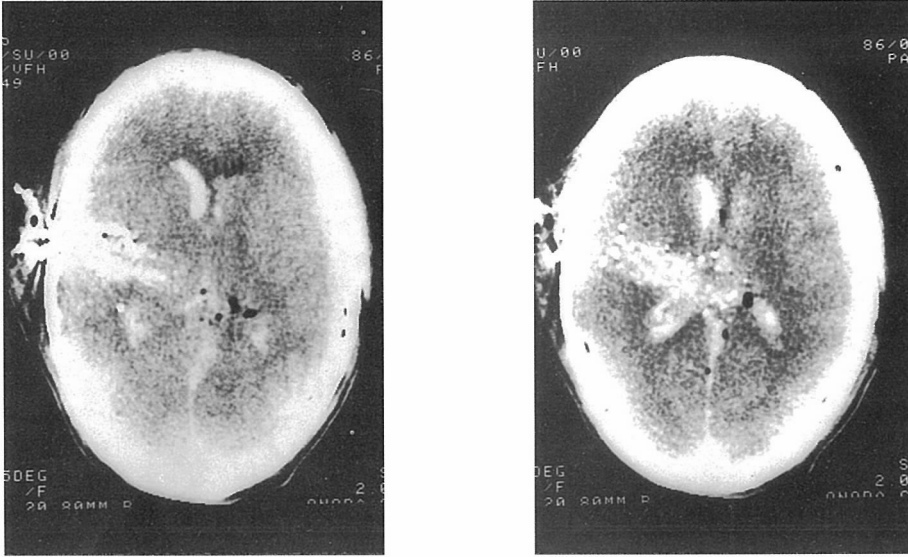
The computed tomographic (CT) scan showed a gunshot tract and hemorrhage of the lateral ventricles.
